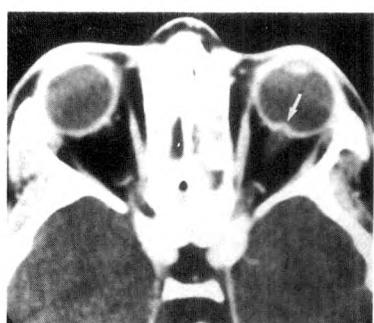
Grade 1 reversal of optic nerve head. Axial 3-mm enhanced CT scan shows optic nerve head reversal bilaterally (arrows), most evident on left side. Note flattening of normal outward convexity at insertion of optic nerve head. Optic nerve sheaths are enlarged bilaterally.
